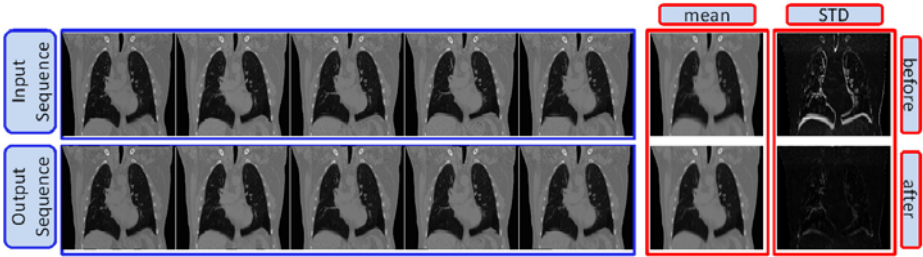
Experiment with CT sequence. Input, output sequences and mean, STD images before and after the registration.
